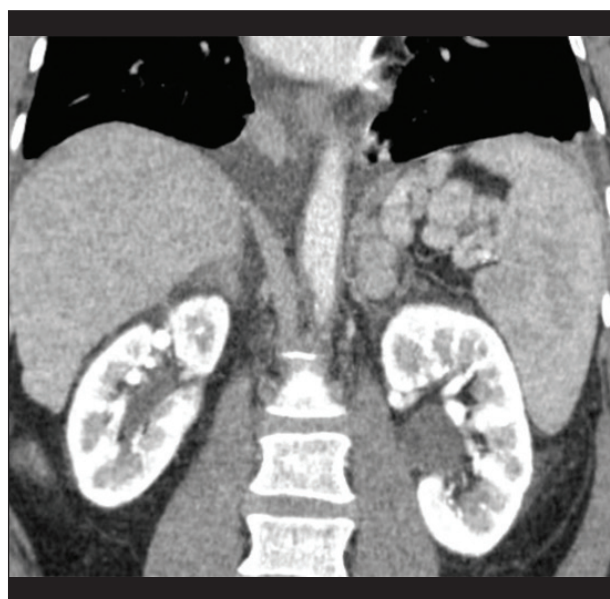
Preprocedural CT scan showing large splenorenal shunt.
